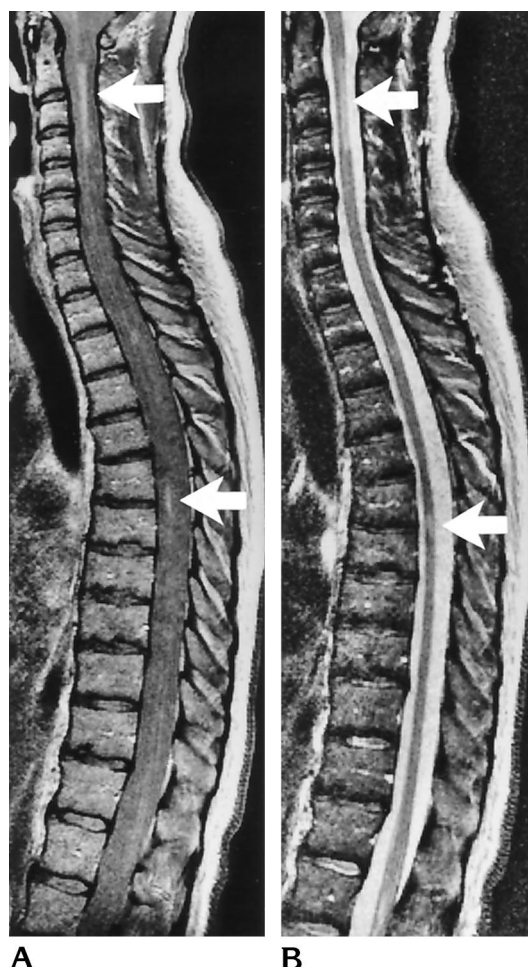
Type I MR finding. Sagittal proton density-weighted (A) and T2-weighted (B) MR images (2200/20,80/1) of a patient with relapsing-remitting MS show only focal lesions (arrows) in the spinal cord. Apart from the focal lesions, the spinal cord and CSF have the same signal intensity on the proton density-weighted image.
